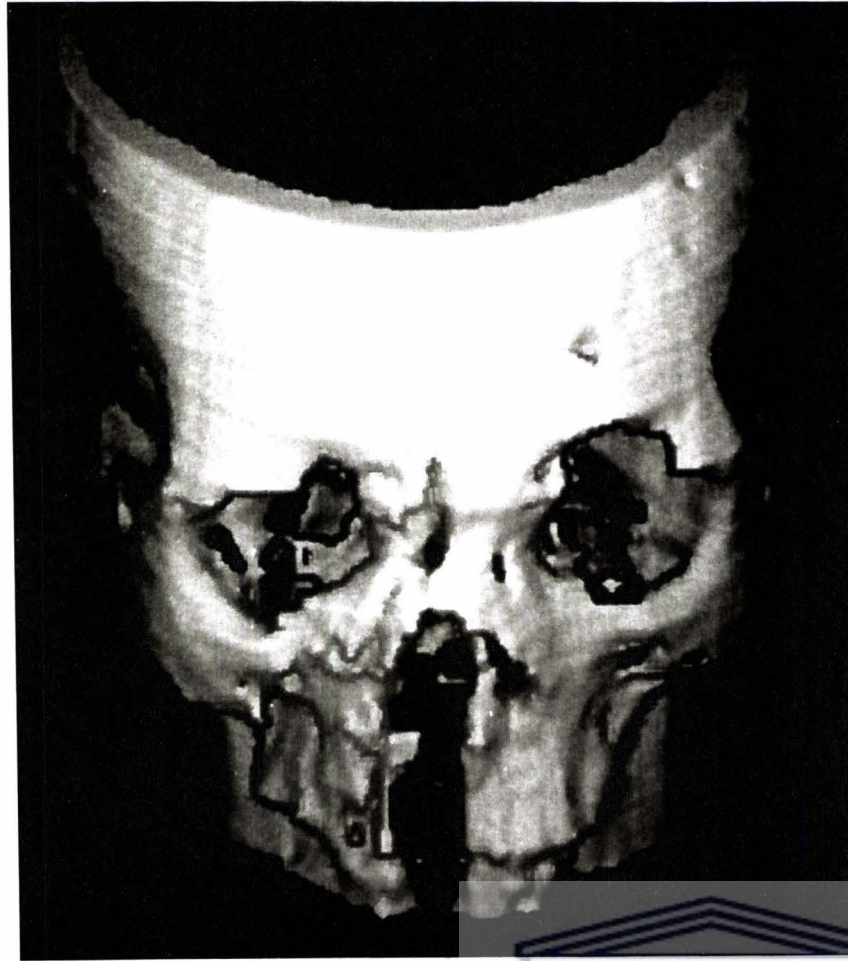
3D — Reconstructed CT-Scan showing skeletal damage caused by an attempted suicide
